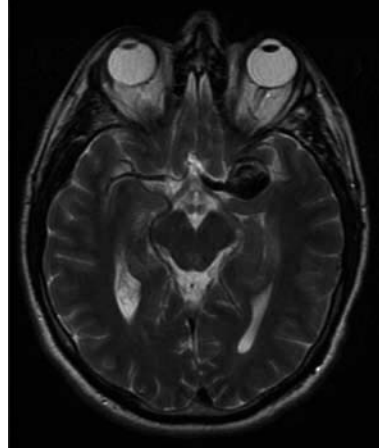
Absence of signal on the magnetic resonance image in the area of the left middle cerebral artery. Giant fusiform aneurysm (2.5 cm).
